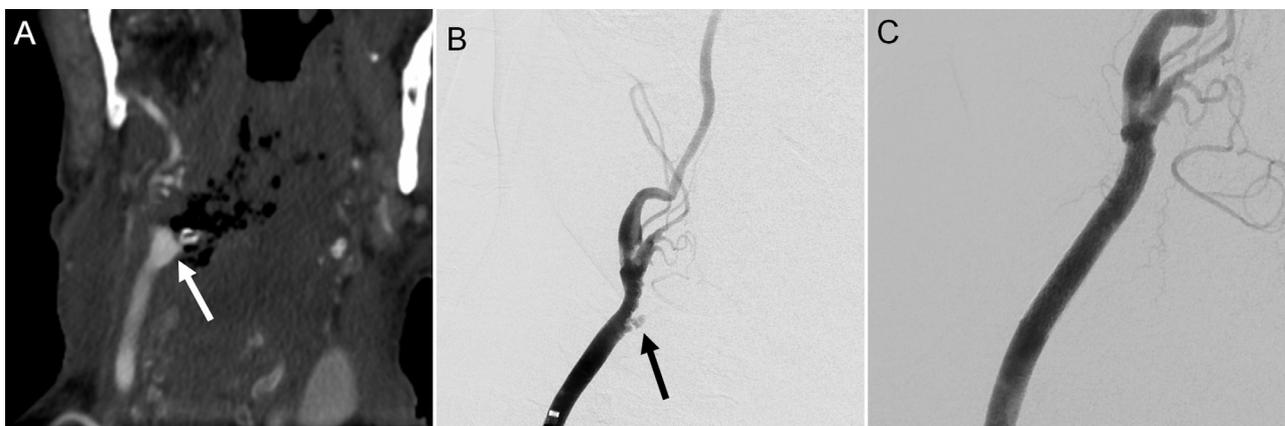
A 75-year-old with a history of laryngeal cancer presents with bleeding from tracheostomy following completion of chemotherapy and radiation five months prior to current presentation. Coronal CTA (A) shows a contour abnormality with a subtle focal bulge along the medial aspect of the right common carotid artery (A, white arrow). Catheter based angiography (B) confirms the focal outpouching arising from the medial aspect right common carotid artery consistent with a pseudoaneurysm (B, black arrow), which was successfully treated with an endovascular stent (C).
